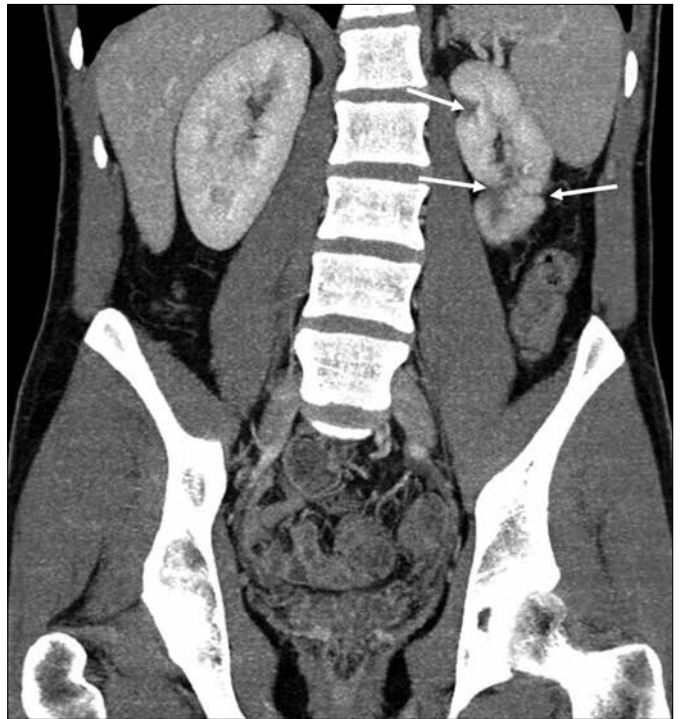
Shows a CT scan one year later without hematoma or urinoma.
